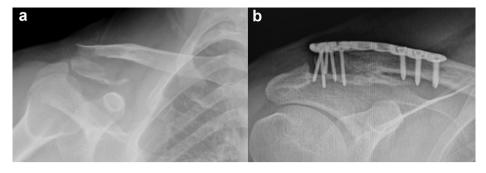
A 36-year-old patient underwent secondary surgery due to dissatisfaction with the cosmetic appearance and screw penetration. Preoperative (a) and 1-year postoperative (b) anteroposterior X-ray views of the patient.
